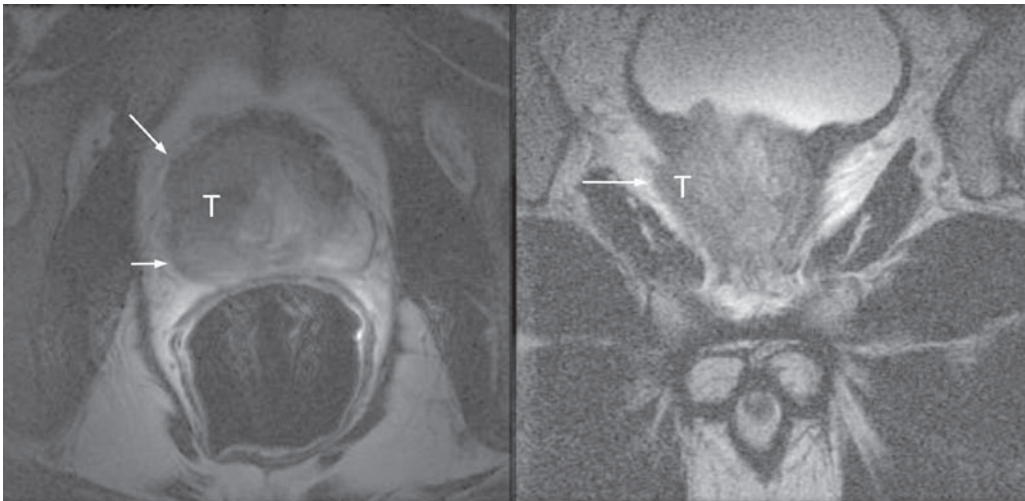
Axial (left) and coronal (right) T2W images, with an endorectal coil at 1.5 T. Patient is a 56-yr-old man with prostate cancer. This staging MRI shows a large right-sided tumor (T). This tumor involves both the PZ and TZ on the right. Both images show extra-capsular extension of disease (white arrows). Thus, this patient has T3 disease.
